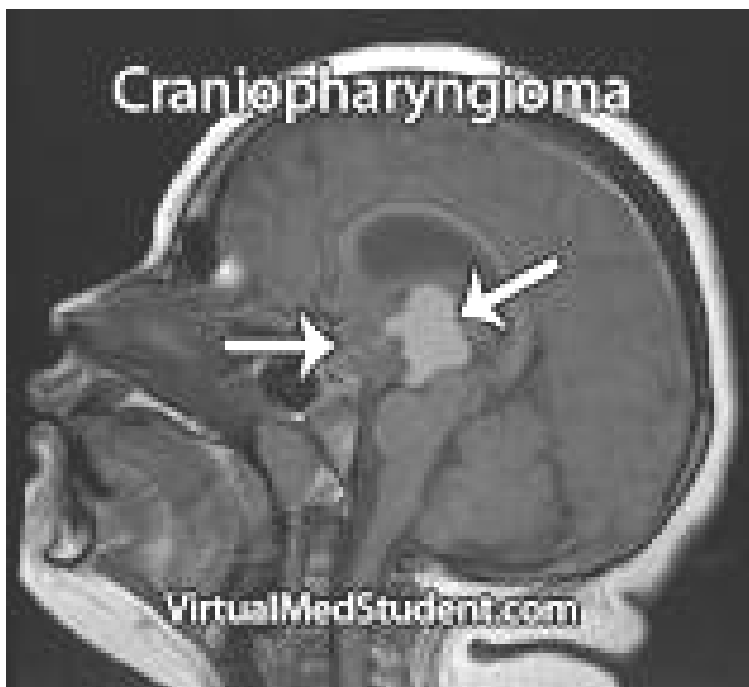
sagittal T1-weighted show craniopharyngioma.
